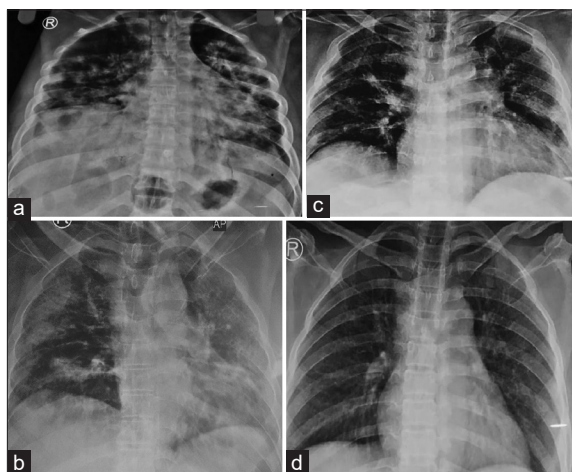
(a and b) Chest X-ray showing infiltrations in >50% lung field. (c and d) Improvement in opacities post dexamethasone pulse therapy
